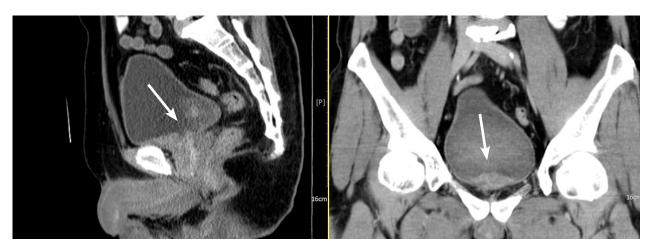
Contrast-enhanced CT study with sagittal and coronal reconstruction views revealed a mass on the anterior bladder neck with intraluminal projection and adherence to the prostatic base.
